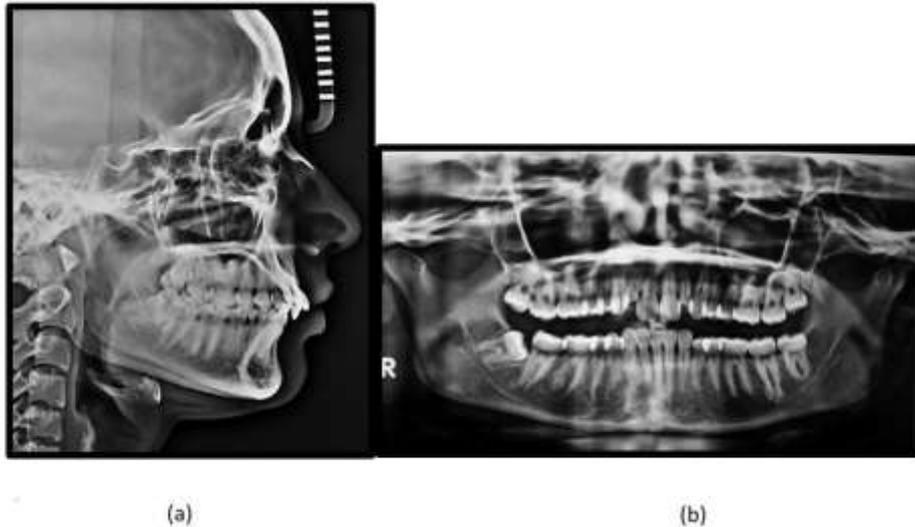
Pretreatment radiographs of the patient (a) lateral cephalogram (b) Orthopantomogram
